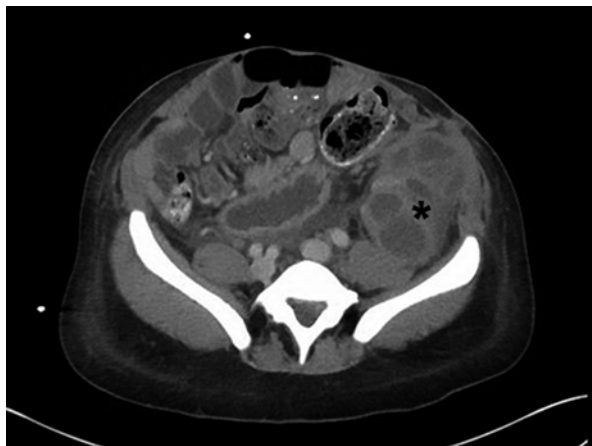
Tubo-ovarian abscess by CT scan. Left-sided tubo-ovarian abscess is indicated with an *asterisk* (\*)
